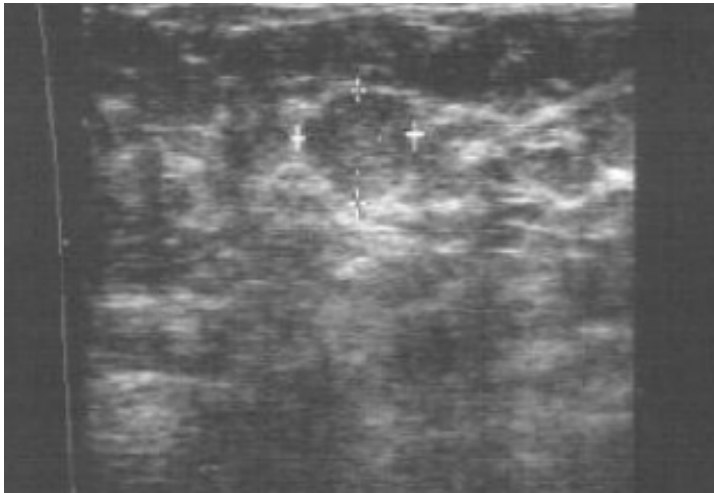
Ultrasound scan of circumscribed breast lesion
